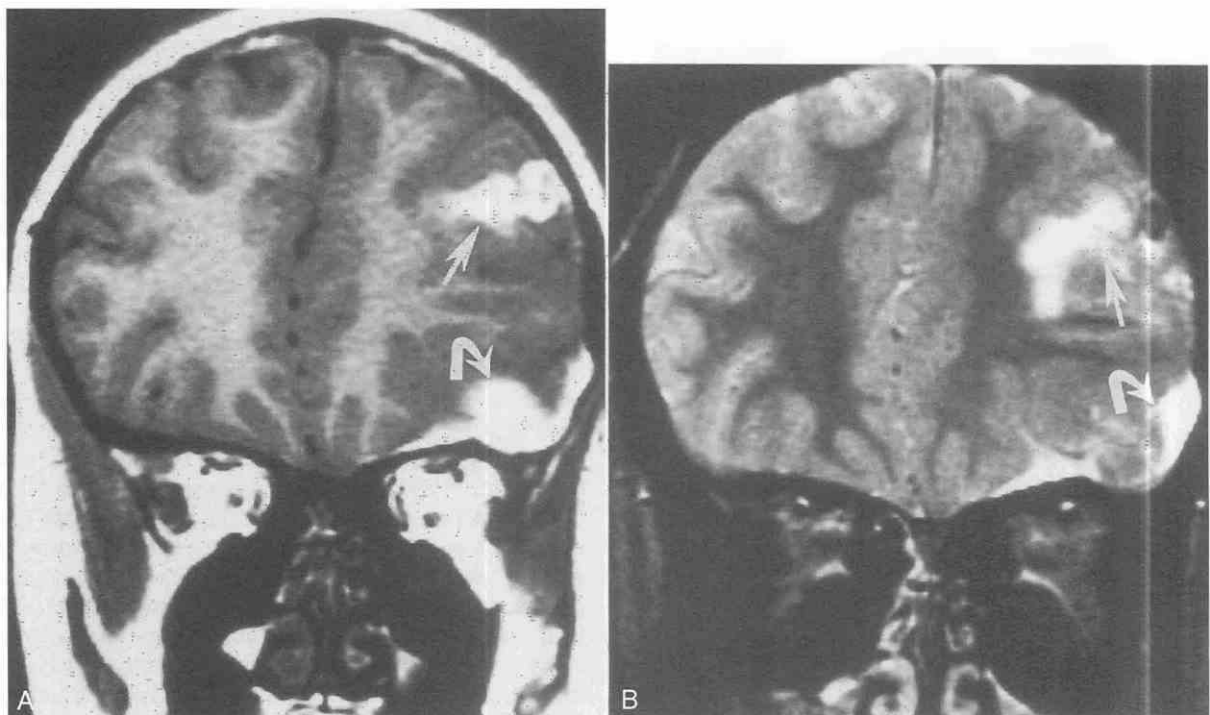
A and B, Subacute hemorrhagic contusion in left frontal lobe is hyperintense on coronal T1-weighted (500/15) and largely hyperintense on coronal T2-weighted (2500/80) MR images, indicating the presence of methemoglobin (arrows). In addition, there is a small left frontal, convexity subacute subdural hematoma (curved arrows).
